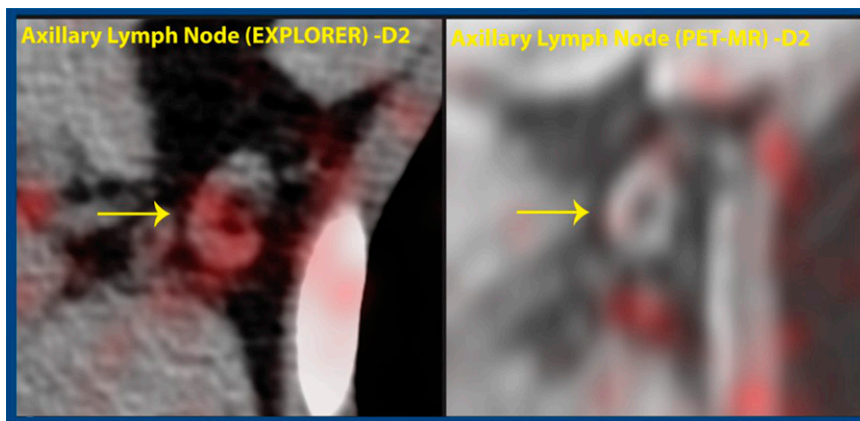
Total-body PET imaging of HIV with ^{89}Zr -VRC01 on the EXPLORER (left) showed increased axillary lymph node (arrows) 2 days after tracer injection compared with conventional PET/MR imaging (right). Increased soft tissue/blood ratios were also seen in patients with active viremia compared with those in patients with antiretroviral therapy suppression.
